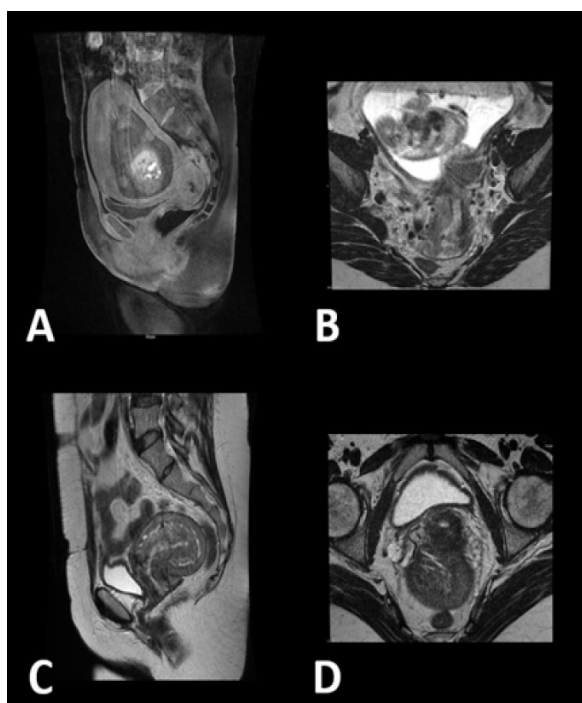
MRI before (A, B) and after (C, D) neoadjuvant chemotherapy
